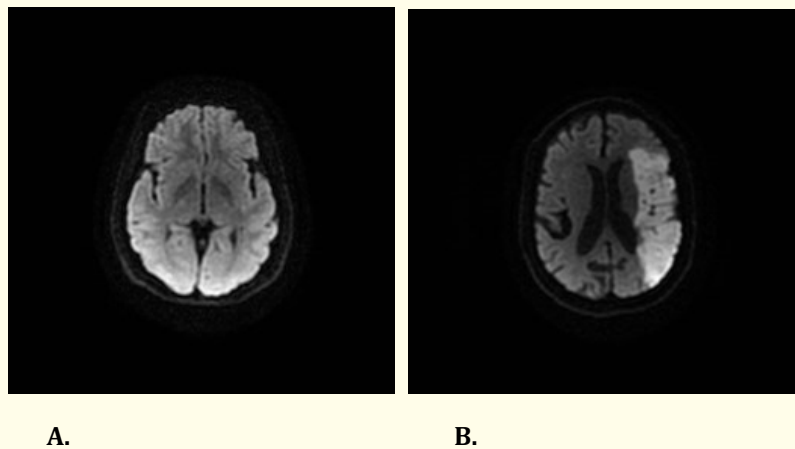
DWI-MRI of two patients presenting with TIA symptoms. A. The first patient had no abnormalities on DWI-MRI, consistent with TIA. B. This patient demonstrated restricted diffusion on DWI, consistent with a left middle cerebral artery territory infarction.
